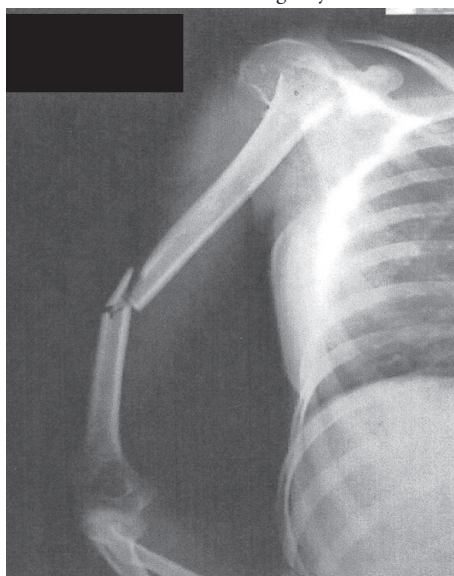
X-ray revealing the bifocal fracture of the right humerus
